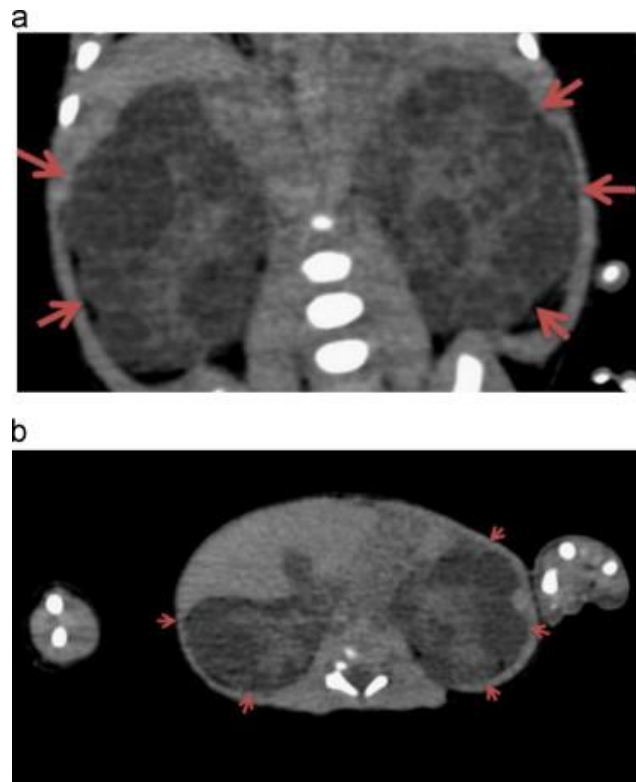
a) Coronal and (b) axial mid-abdomen cross-sectional CT image used for the diagnosis of Autosomal Recessive Polycystic kidney disease (ARPKD) in Saudi Arabia. Figure reprinted with permission from Algerian K, Alhawas A, Alqahtani S, Golding B, Alkahtani T (2015) First virtual autopsy in Saudi Arabia: A case report with literature review. *J Forensic Radiol Im* 3 (1):76-79. doi:10.1016/j.jofri.2014.11.002 [79]
